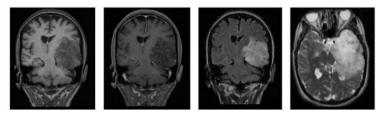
Different imaging modalities for a patient diagnosed with a glioma tumour. From left to right, T1-weighted, T1-enhanced, FLAIR and T2-weighted MR image.
